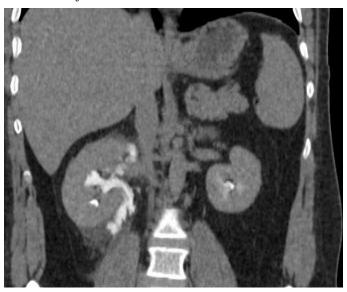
Coronal view of the abdominal CT shows contrast extravasation from the right upper ureter
